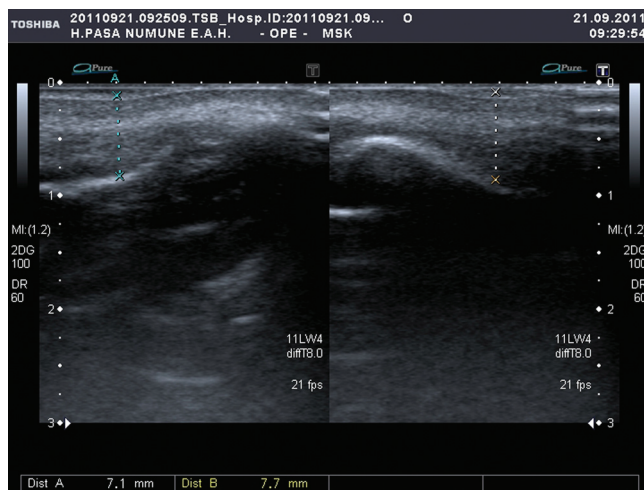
Measurements of skin thickness at the right and left midportions of the nostrils in ultrasound images. Concavity of the lower lateral cartilages is clearly seen.
